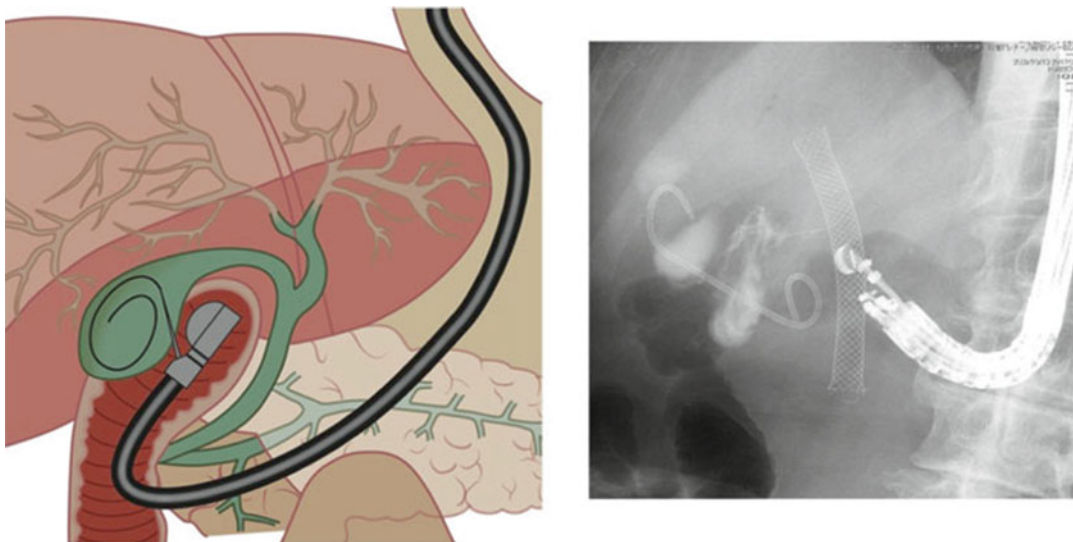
Endoscopic ultrasound-guided gallbladder drainage (EUS-GBD) technique. Figures from Tsuyuguchi et al. [6]
